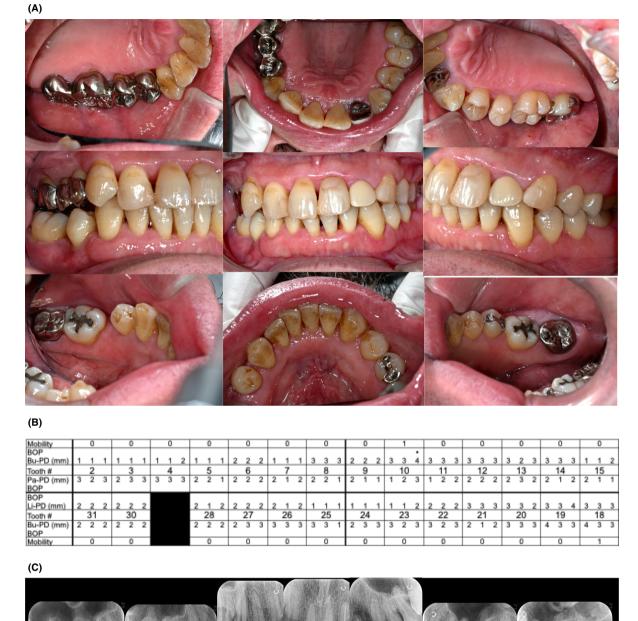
Periodontal status of the patient after periodontal treatment and ascorbic acid supplementation. (A) recent periodontal images revealed no recurrence of gingival overgrowth (January, 2014), (B) periodontal chart revealed a significant reduction in pocket probing depths and in the number of BOP-positive sites compared to the first visit, (C) radiographic evaluation revealed that a stable alveolar bone level was maintained during supportive periodontal therapy (October, 2013).
